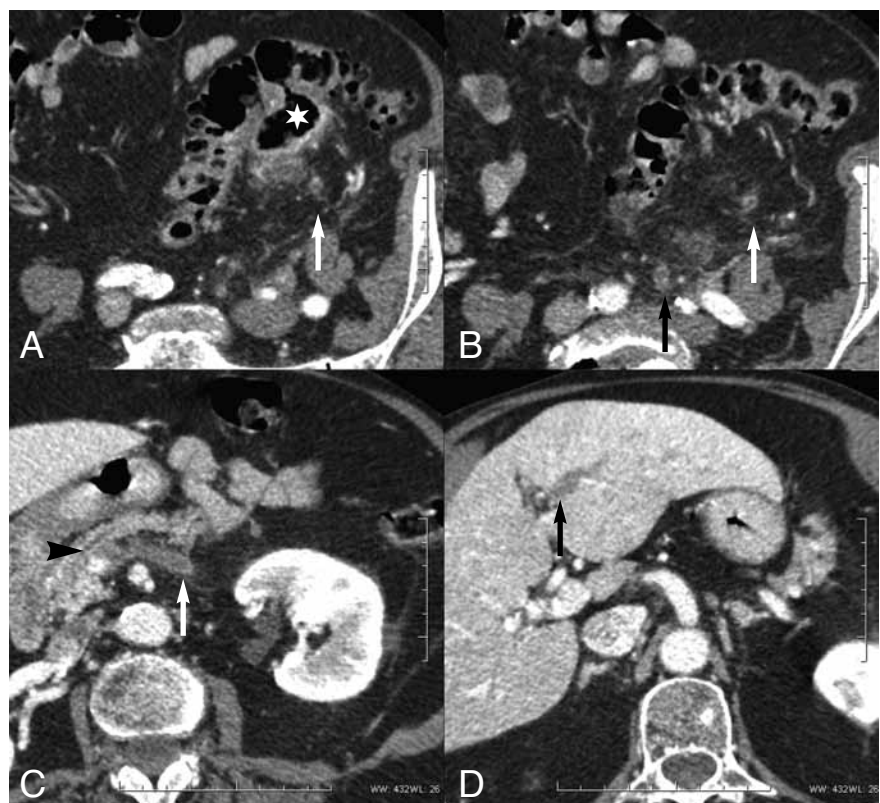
Contrast enhanced CT. CT parameters were 120 kV, modulated mAs, 15671.19CTD/vol of mGy, DLP mGy-cm and 8,5 mSev. A : large pericolic aeric cavity (star) with adjacent blurring of the fat and thrombosis (straight arrows) of the veins in the mesosigmoid fat. B: axial slice at the level of the iliac vessels. Thrombosed sigmoid vein (white arrow). Thrombosed inferior mesenteric vein (black arrow). C: at the level of the pancreas. Thrombus (white arrow) in the area of the confluence of inferior mesenteric vein and splenic vein. Distal end of the thrombus (arrow head). D: thrombus in the left portal vein (arrow) but no intra-hepatic abscess.
